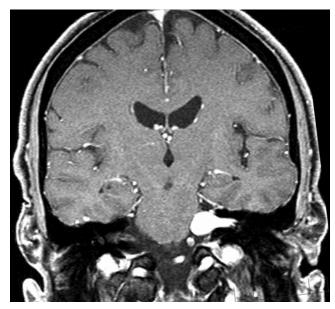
Coronal T1-weighted Gd-enhanced MR image demonstrating a VS of dimensions consistent with our base case.
